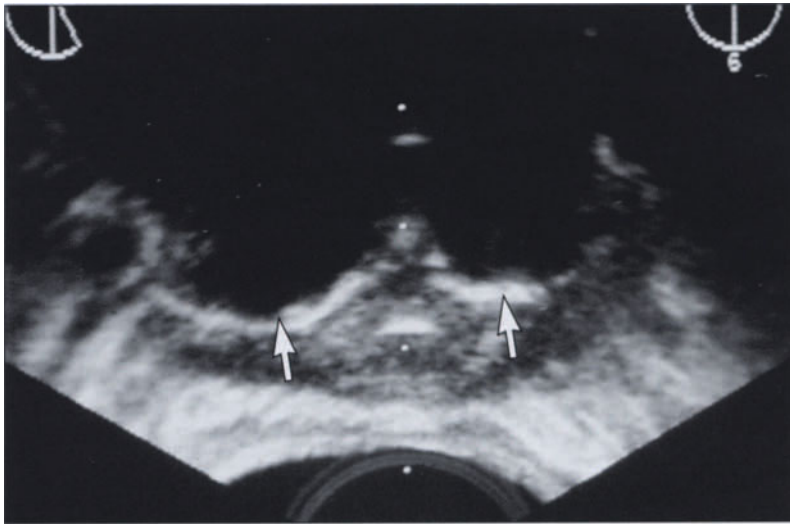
Ultrasound image of frozen tissue. In this transverse sectional transrectal ultrasound image of the prostate gland during cryosurgery, the edge of the ice ball is seen as a highly echogenic line with acoustic shadows behind it (*arrows*). Because the sound impedance drastically changes from the frozen tissue to the unfrozen tissue, most of the sound waves are reflected at the interface, creating the strong acoustic shadow. Beyond this interface, nothing can be monitored by ultrasound because of this artifact. The temperature at the leading edge of ice is approximately 0°C.
